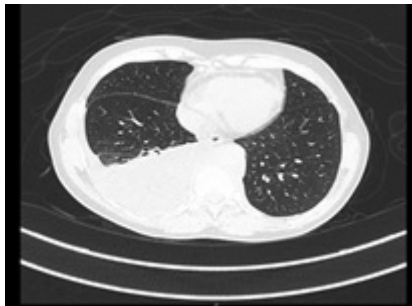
CT image of thorax (lung window).
